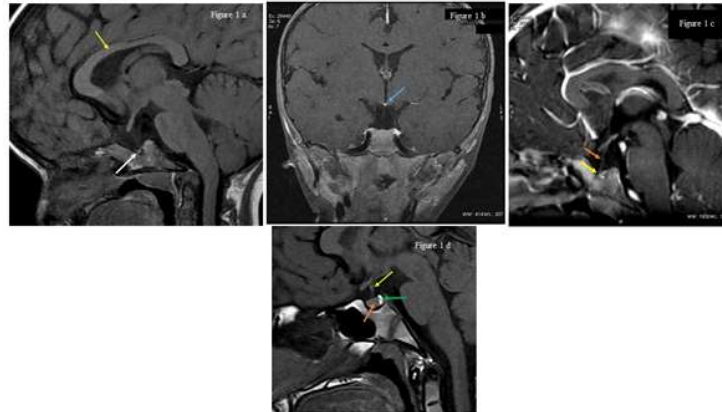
a-Sagittal T1W MRI reveals hypoplastic anterior pituitary gland (white arrow). Normal corpus callosum noted (yellow arrow). Fig 1. b-T1W coronal MRI shows ectopic location of posterior pituitary bright spot at the median eminence (blue arrow). Fig 1. c –post contrast T1W sagittal zoomed images- shows hypoplastic anterior pituitary gland (yellow arrow) and hypoplastic infundibulum (orange arrow). Fig 1. d- T1W sagittal images shows normal pituitary gland for comparison (orange arrow-anterior pituitary gland, green arrow-posterior pituitary bright spot at normal location and yellow arrow- pituitary stalk).
